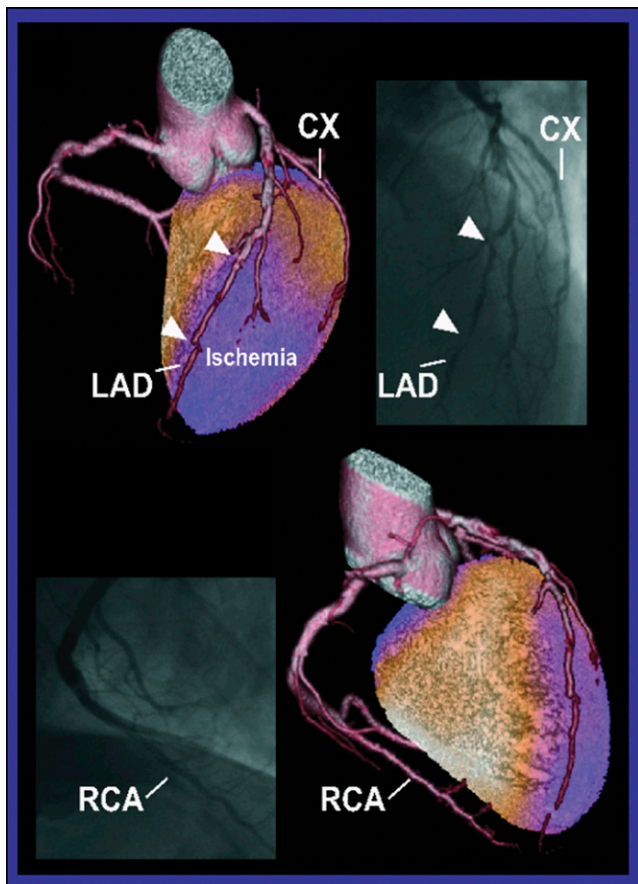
Images obtained with SPECT/CT angiography (top left and bottom right) accurately predicted the results of subsequent invasive angiography (top right and bottom left).
